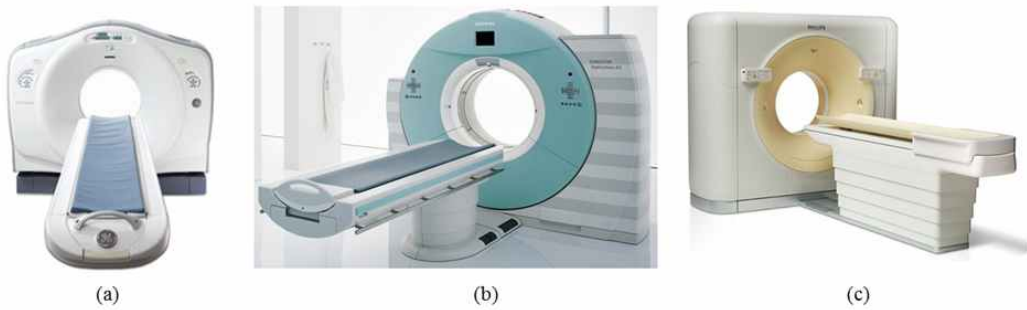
MDCT scanners (a) GE Healthcare, LightSpeed CT750 HD (b) SIEMENS, Somatom Definition AS (c) Philips, Brilliance CT 16 Slice
